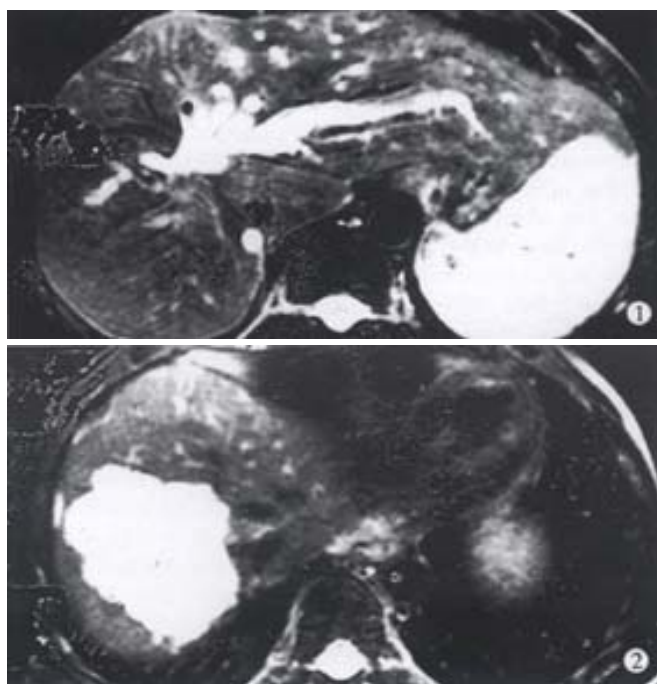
Hepatobiliary damages 6 years after HAE with sod. morrhuate: MRI showed atrophy of right liver, hypertrophy of the left lateral segment and obstruction of hepatic duct at the hila hepatis.
